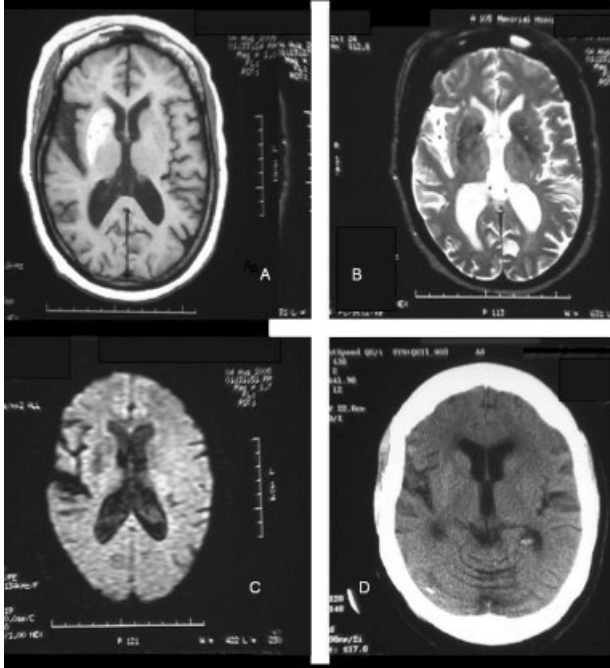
Brain magnetic resonance imaging showed hyperintensity T1-weighted (A), hypointensity T2-weighted (B), and nonrestricted diffusion-weighted imaging (C) of right caudate and putamen. Axial brain CT scan (D) showed hyperdensity of right caudate and putamen.
